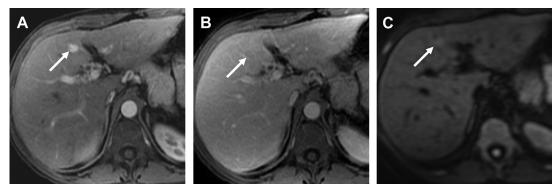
A 37-year-old woman with history of common variable immune deficiency (CVID). Axial MR image obtained during hepatic arterial phase (*A*) shows an avidly enhancing lesion in segment 2 (*arrow*) which becomes isointense to the background liver during the venous phase (*B*). The lesion showed mild hyperintensity on diffusion-weighted image (b value = 500 s/mm²) (*C*). Biopsy was consistent with nodular regenerative hyperplasia.
